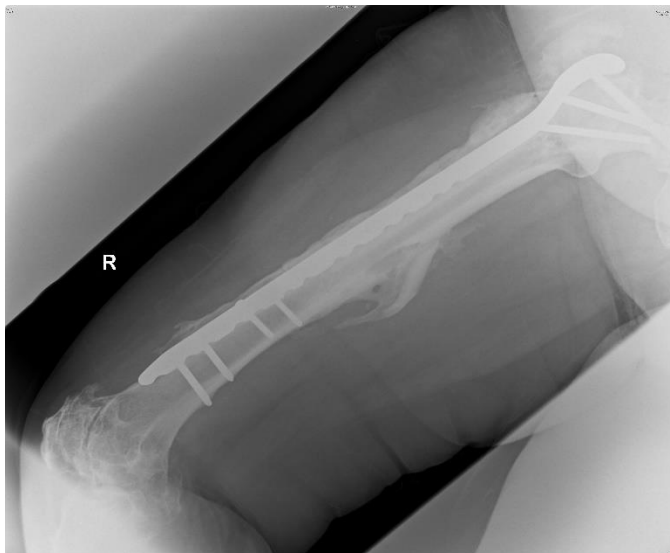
Anteroposterior radiograph of the right femur on presentation (nine years after index trauma) shows a healed fracture with significant peri-implant new bone formation/involucrum.
